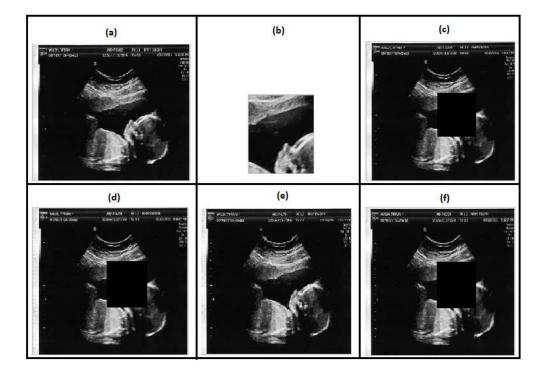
(a) The original host Ultrasound image, (b)ROI image of host image,(c)Roi removed image (c)Emebedded image without ROI, (d)Final embedded image with ROI
